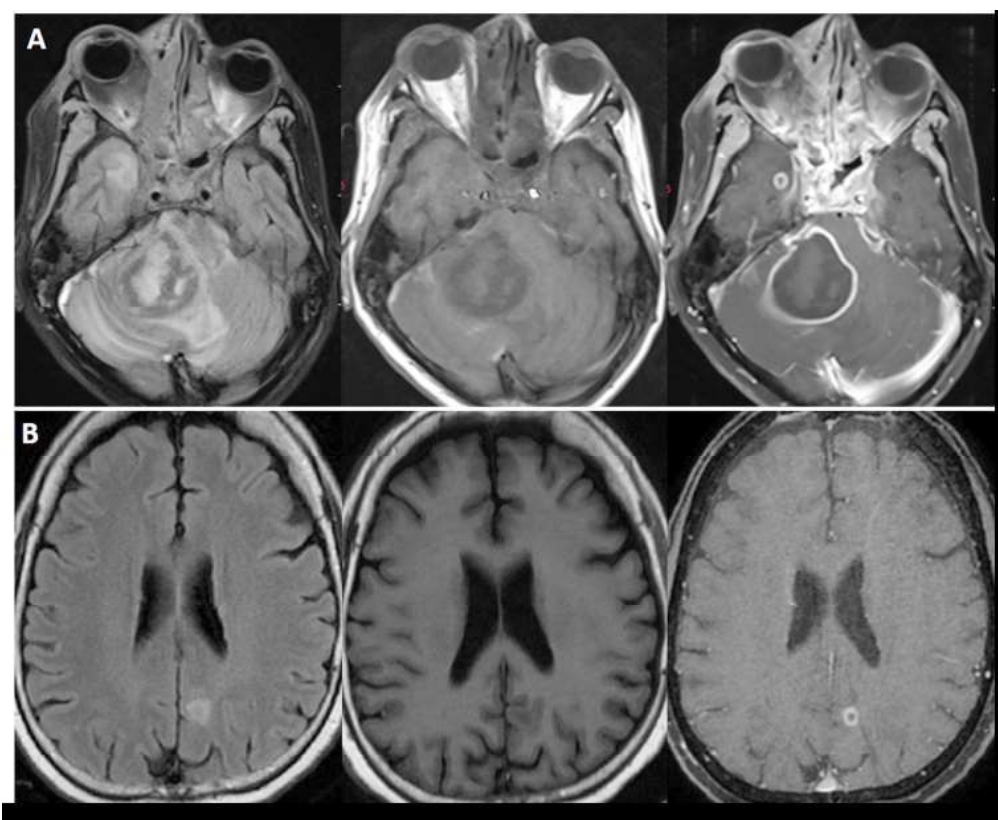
FLAIR, T1W and T1W contrast axial MRIs. A: a well defined FLAIR iso-hyperintense fungal abscess involving ventrolateral aspect of right cerebellar hemisphere, right pons, middle cerebellar peduncle with peripheral enhancement, mass effect and compression of fourth ventricle. It is contiguous with the right cavernous sinus involvement. Smaller abscess is seen the right anterior temporal lobe. B: a small abscess in the left parietal lobe (non-contiguous to the rhino-orbital disease)
